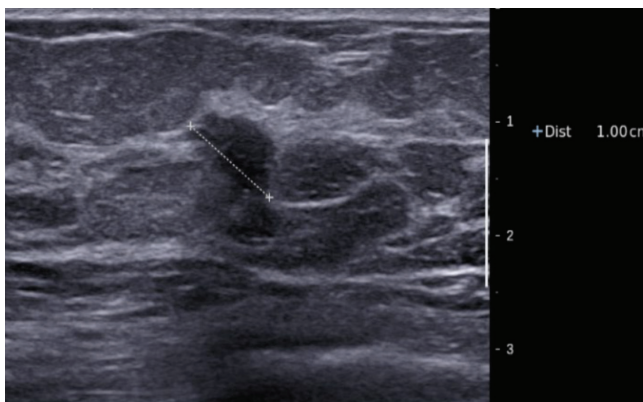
The breast ultrasound found a hypoechogenic mass, with irregular contours and a large vertical axis
